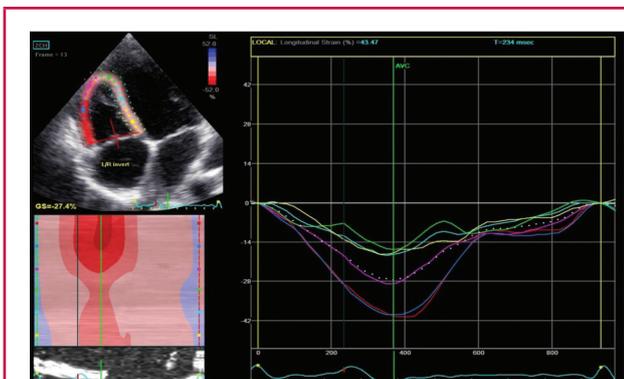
Two-dimensional speckle-tracking imaging in the apical four-chamber view: right ventricular strain.
